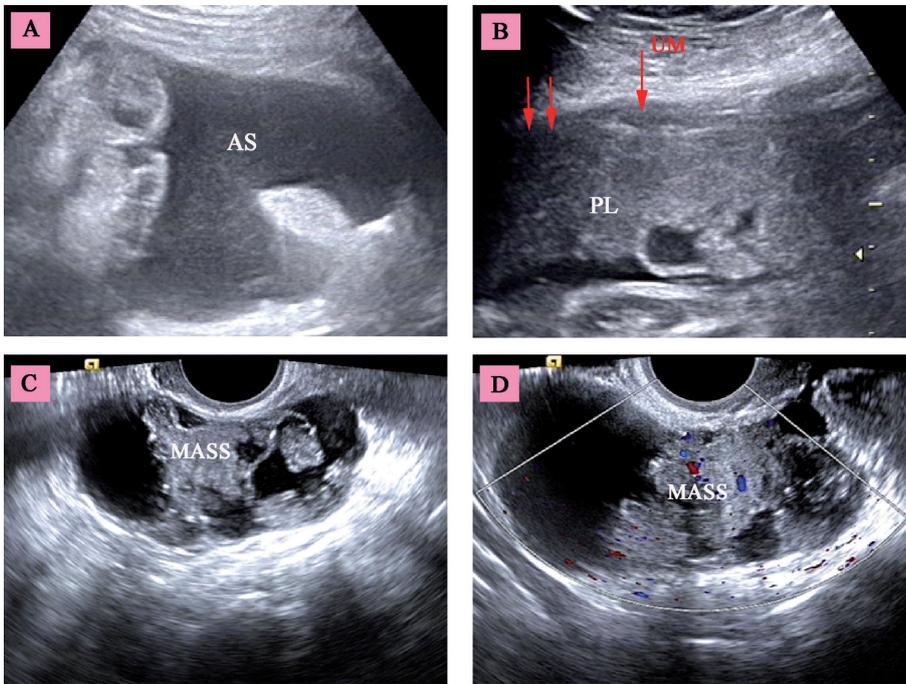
Ultrasound findings before the initial operation. A) AS (ascites). B) PL (placenta). The UM (uterine myometrium) that the middle arrow indicates a clear low echo. The left two arrows indicate the right cornua uteri, whose myometrium is unclear. C) and D) The ultrasound findings before the second operation. There is a solid-cystic mass of the left ovary. D) Image of color Doppler, in which blood flow signals in the mass can be found.
